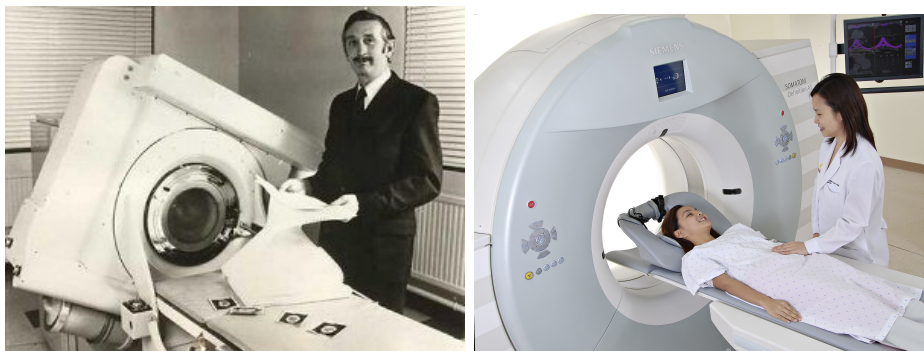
On the left: a famous picture of Mr. Hounsfield and his first prototype of head CT machinery. On the right: modern CT device, made of a gantry (a donut-shaped open structure) and a patient-bed that can slowly move through the gantry.
